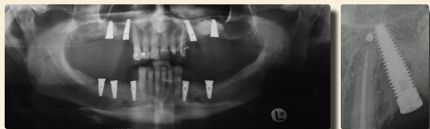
Orthopantomogram showing final position of endosseous implant
